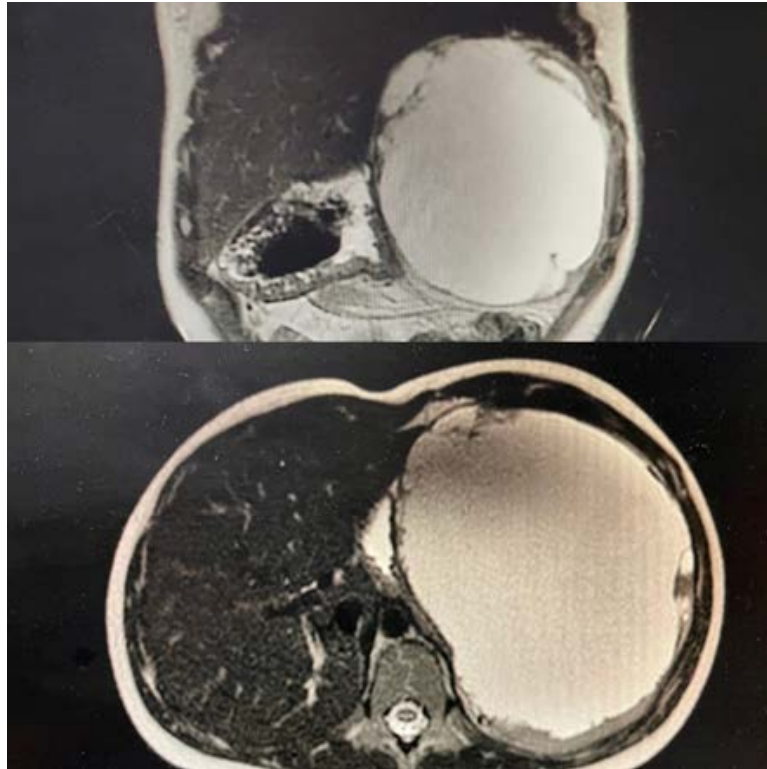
Magnetic resonance imaging – the second patient
